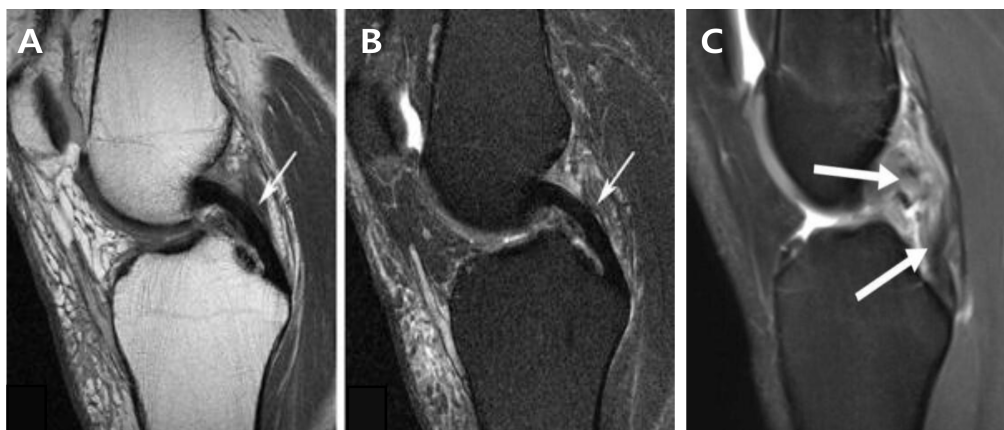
Normal and Abnormal PCL on MRI. (A) Normal PCL with Sagittal T2WI view (B) Normal PCL with Sagittal PD view (C) PCL tear with sagittal PDWI view.
